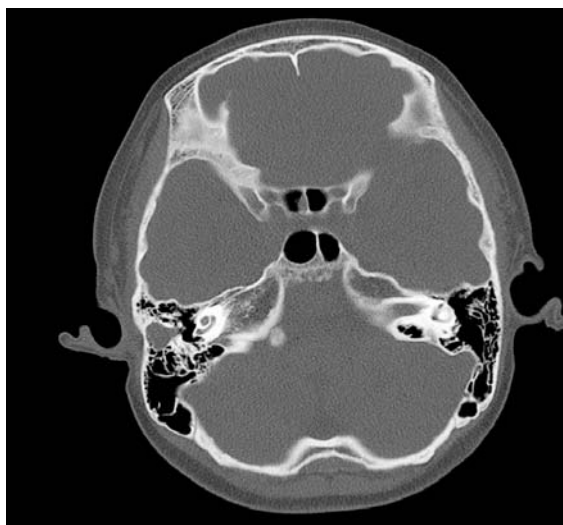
CT scan result of case No. 66 (male, 11 years old). Right side: microtia grade I with external meatus stenosis. Left side: normal. CT scan showed right-sided middle ear cholesteatoma and deformed ossicles.
